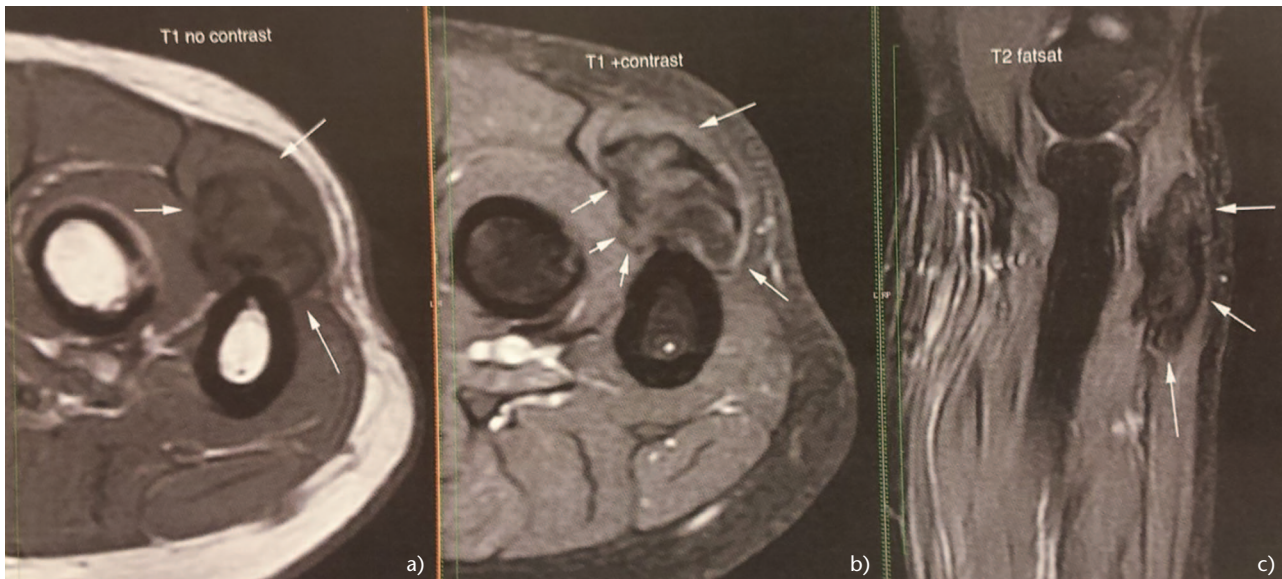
Elbow schwannoma in a 58-year-old female. Magnetic resonance imaging showing the 1.3 x 1.3 x 3.6 cm mass abutting the proximal ulna. (A) Axial T1. (B) Axial T1 with contrast. (C) Sagittal T2 fat saturated sequence of the mass.
